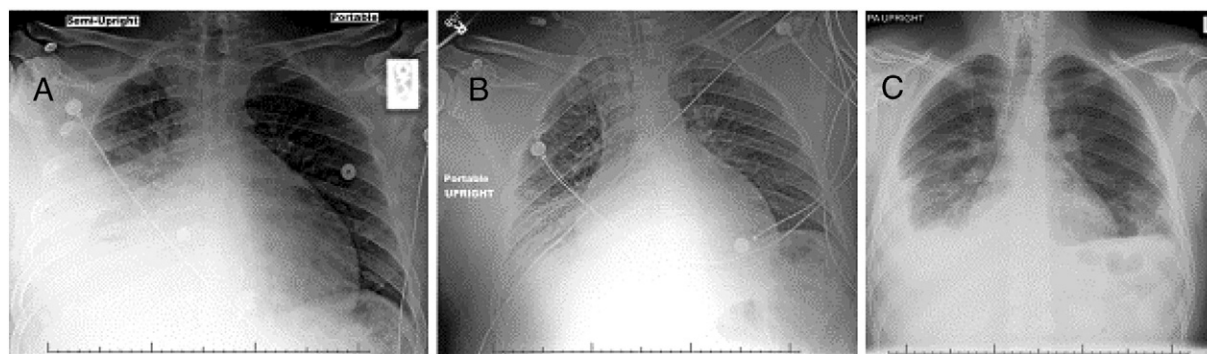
Preoperative chest radiograph showing markedly increased, globular cardiac silhouette and right pleural effusion (A). Persistent cardiac enlargement on postoperative chest film (B), and for comparison, the normal heart size 17 days after surgery (C).
